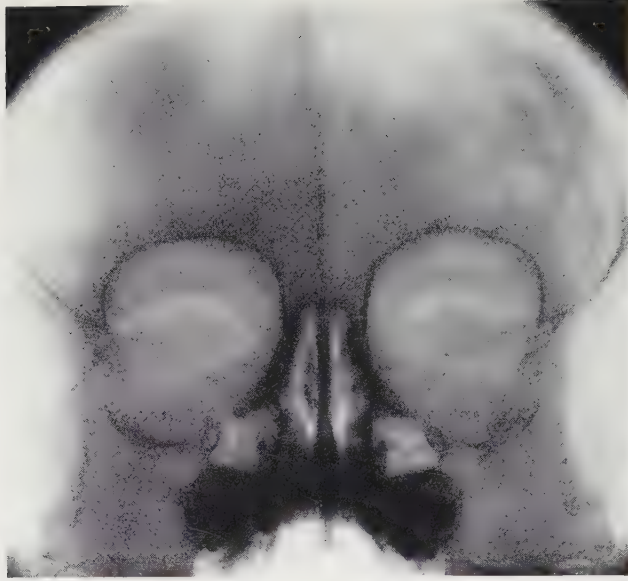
Half-axial roentgenogram of the skull of a nineteen-month-old child with Trigonocephaly and hypotelorism. The interorbital distance of this case is 1.35 cm.
